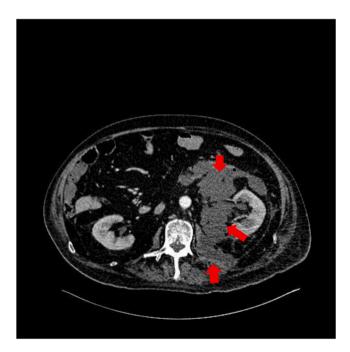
Abdominal CT revealing multiple retroperitoneal abscess (red arrows) of different sizes located throughout the left flank.
